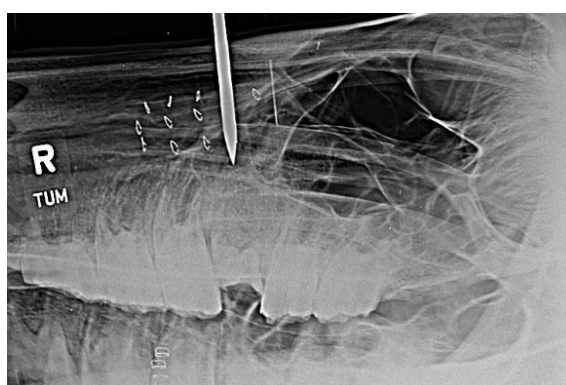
Staple and radiographic image for pin placement
